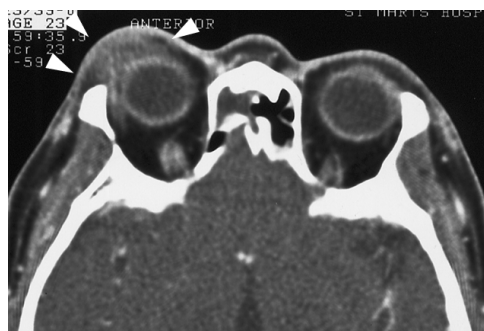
Xanthogranuloma in a 62-year-old woman. A contrast enhanced axial CT scan shows poorly enhancing, soft tissue density infiltrations at the anterior lateral aspect of the right orbit (arrowheads).
